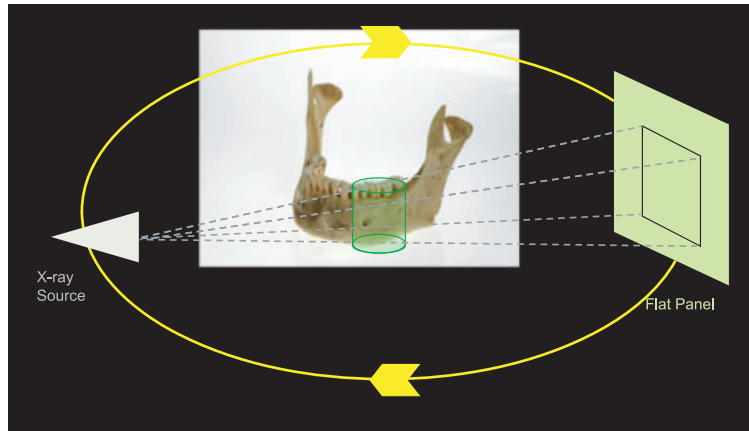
A cone-shaped X-ray beam and the detector rotate once around the patient and captures a cylindrical volume of data (field of view).
